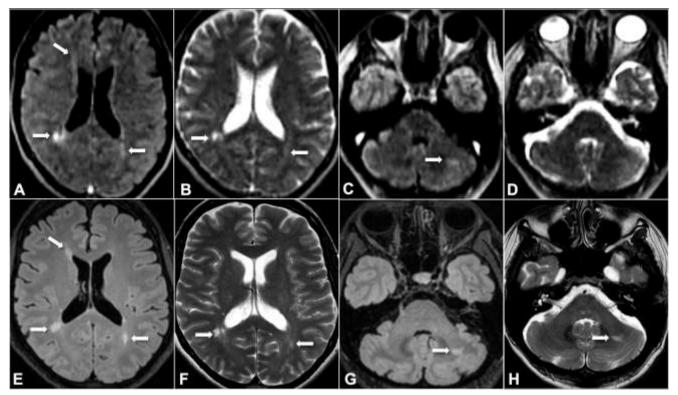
Concordant DIS in 47-year-old female with optic neuritis. Axial T2-FLAIR (A, C, E, G) and T2-FSE (B, D, F, H) images on 64mT pMRI (top row, A-D) and 3T cMRI (bottom row, E-H) show multiple supratentorial lesions (A, B, E, F) and a left cerebellar lesion (C, G, H) identified on both 64mT and 3T. The left cerebellar lesion was seen on the T2-FLAIR (C) but not well depicted on the T2-FSE (D) pMRI sequence.
